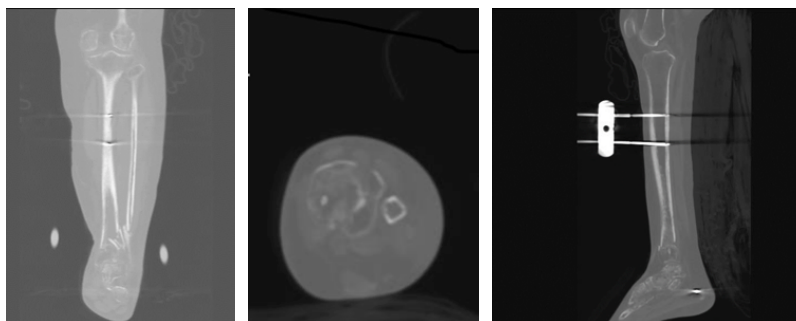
A pre-operative CT scan showed just a shell of cortical bone and a significant metaphyseal void.
